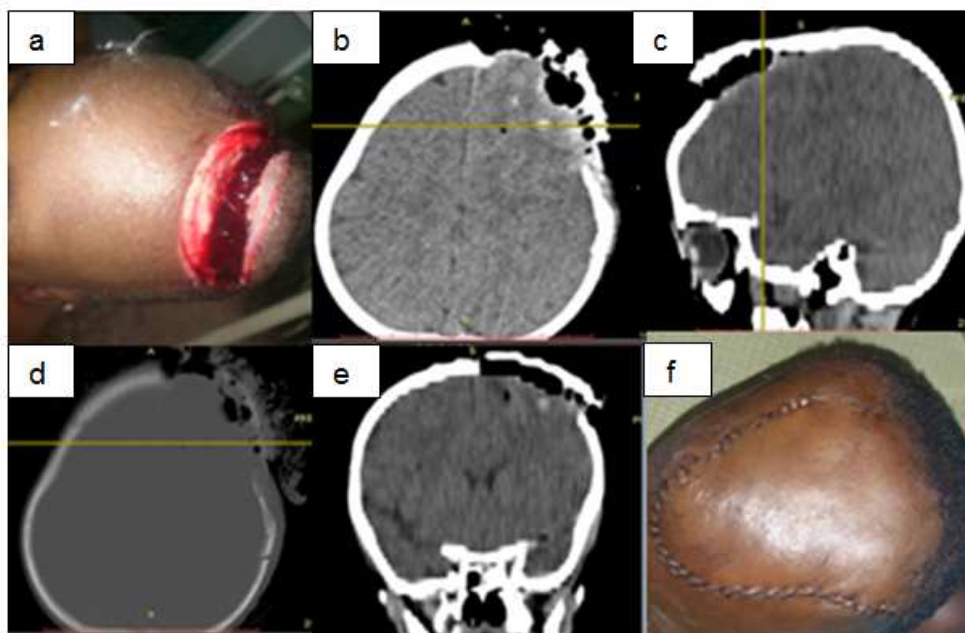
Showing Pre-operative (a), CT Scan (b-e) and Post-operative images of case 1.
